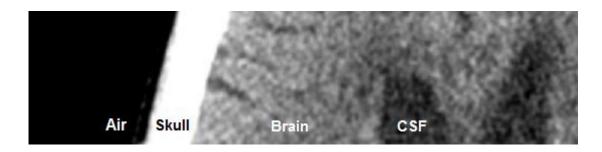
CT brain densities showing different appearances.
